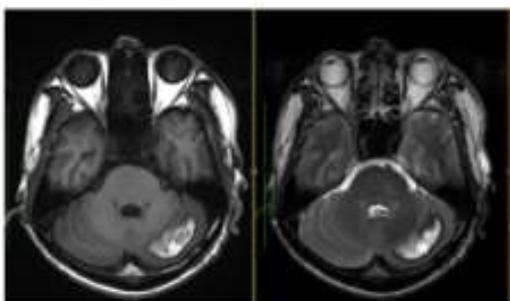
Brain MRI T1W and T2W showed subacute in intracerebellar haemorrhage (8)
